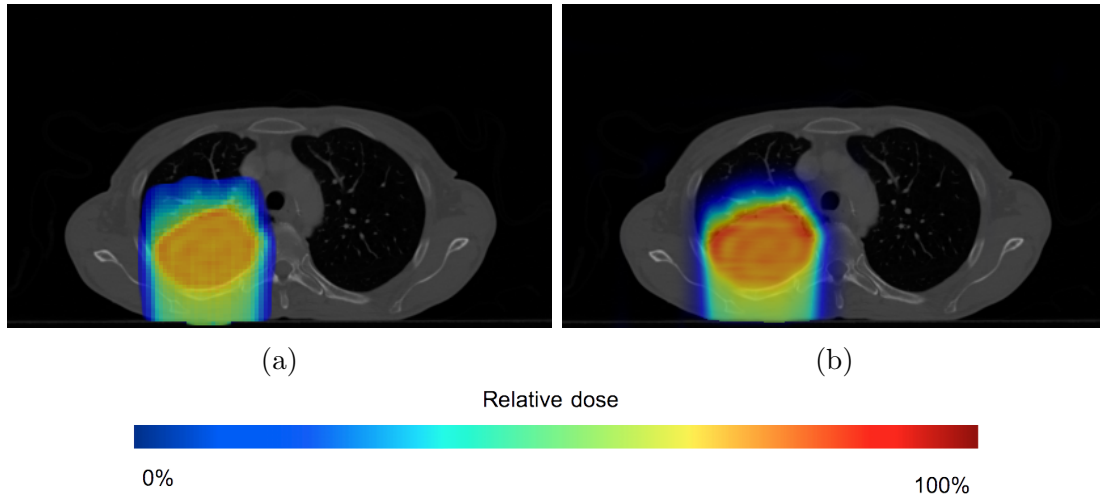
Dose distributions computed in *ProtonMachine* (4.12e) and in MSPT (4.12f) overlaying the patient CT image (transverse plane located near the middle of the tumor).
